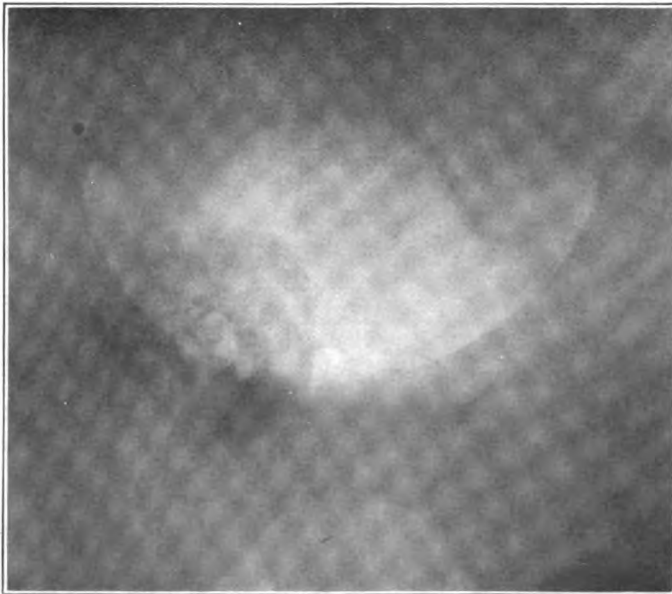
Roentgenogram showing outline of air filled bladder with overlapping shadow of ovarian dermoid cyst containing teeth and lower mandible.
